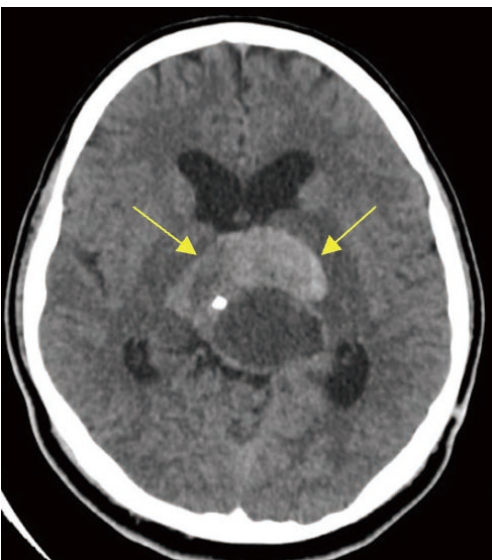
Post-operative plain CT scan of the brain in axial view showing an increase in size and intra-tumour bleed.
